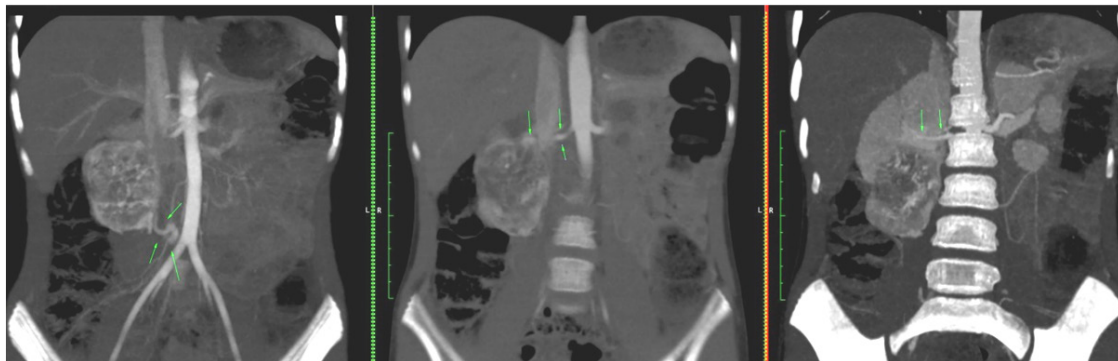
Patient, 9 years old. Contrast preoperative MRI: Heterotopic pheocarcinoma? Renal paraganglioma?
